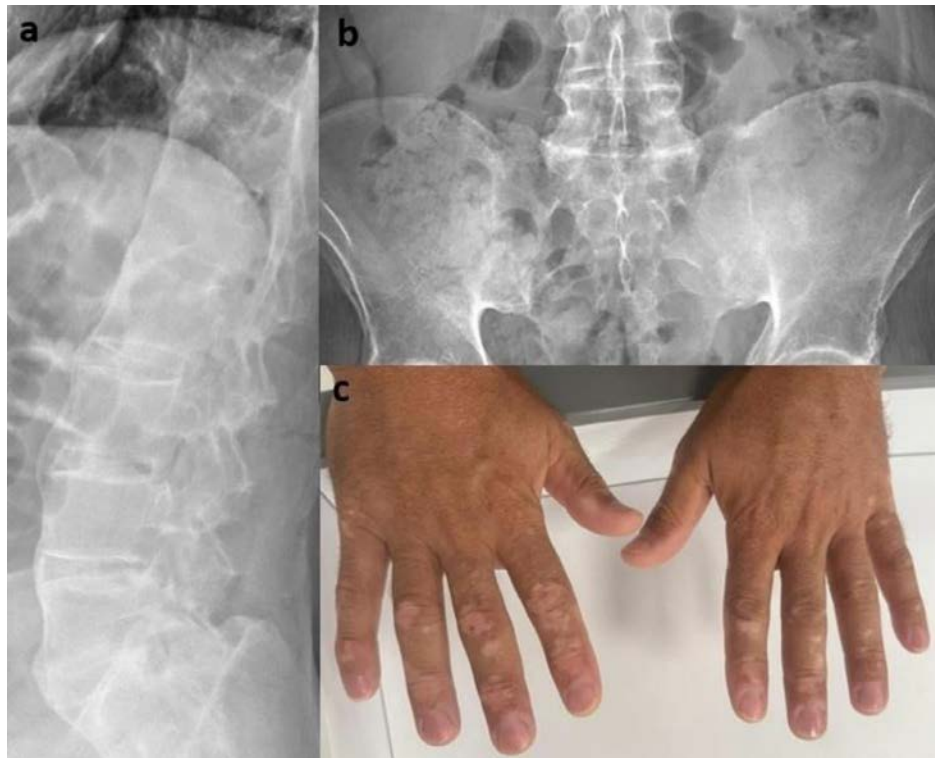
(a) Lumbar radiograph of a patient with ankylosing spondylitis demonstrating the characteristic “bamboo spine” appearance; (b) Pelvic radiograph showing bilateral grade 4 sacroiliitis according to the modified New York criteria; (c) Hypopigmented patches on the dorsal surfaces of both hands, consistent with vitiligo.
